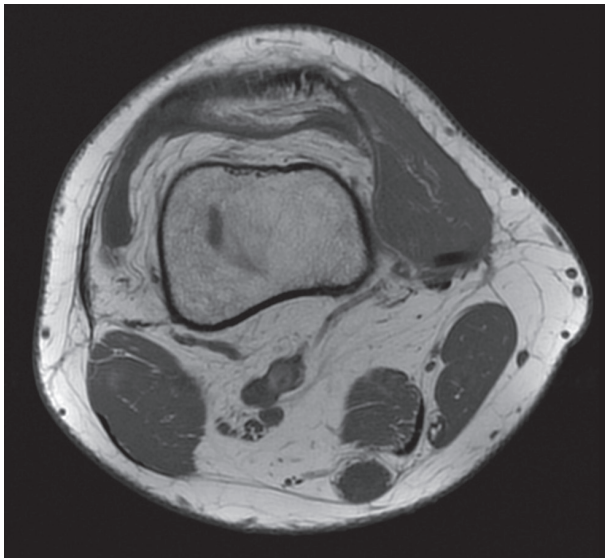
MRI T1 image shows pin complete migration in medial distal femoral soft tissues
